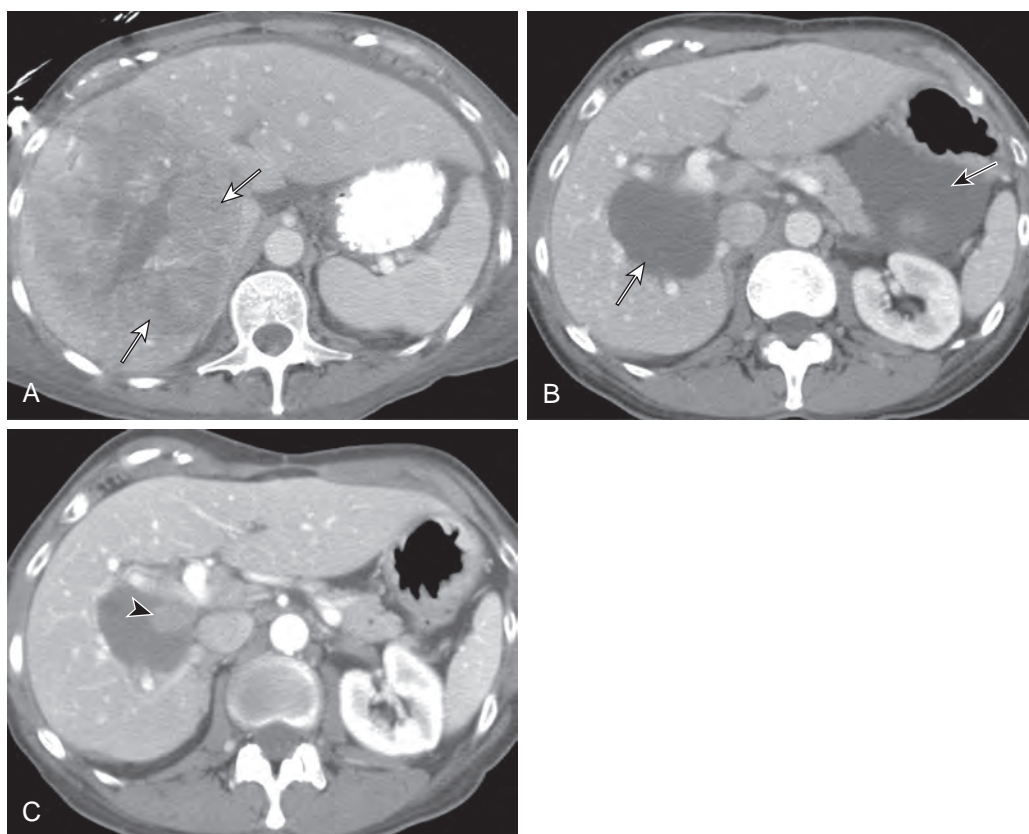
Treatment-related changes of GIST metastasis. This 69-year-old woman had a GIST and liver metastasis. A. Axial CT shows a metastasis of 10+ cm in the right lobe of the liver (arrows). B. Nine months after therapy with imatinib, the liver metastasis (white arrow) is smaller and completely cystic-appearing, without solid elements. It could be mistaken for a benign cyst if the prior examinations are not available. New-onset ascites (black arrow) is present and was misinterpreted by the radiologist as heralding peritoneal metastases. Ascites may be drug-induced and should not be reported as indicating tumor progression in the absence of solid mesenteric nodules. Imatinib is known to cause hypoalbuminemia, and albumin levels are used to determine the efficacy of therapy. The dose of imatinib was reduced because of the presence of moderate hypoalbuminemia. C. Axial CT performed 4 months later shows a mural nodule (arrowhead), a finding that indicates recurrent tumor. A new-onset mural nodule may be the only feature of tumor recurrence.
